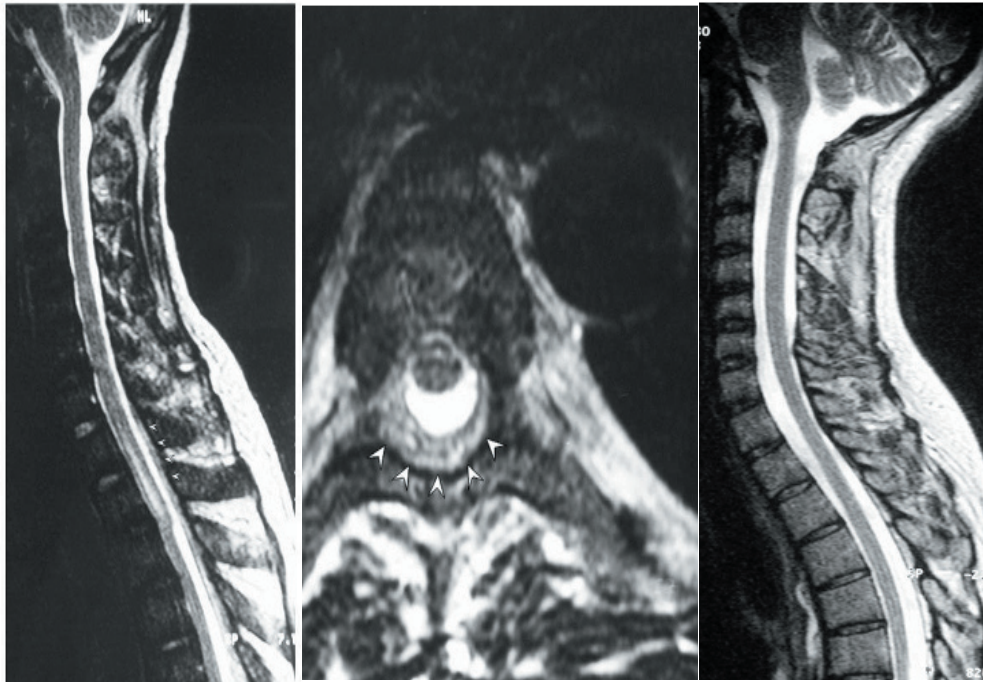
Sagittal spin-echo T2-weighted MR image of the mid-thoracic spine shows extensive decreased signal intensity throughout the vertebral bodies due to increased production of red blood cells and clearly reveals posterior epidural mass. Figure 1B. The masses are hyperintense compared with spinal cord on axial spin-echo T2-weighted MR images. Figure 1C. On axial spin-echo T2-weighted MR image the close relationship of the epidural masses with the spinal cord and the nerve roots is better delineated. There is also high signal intensity in the spinal cord at the level of compression.
